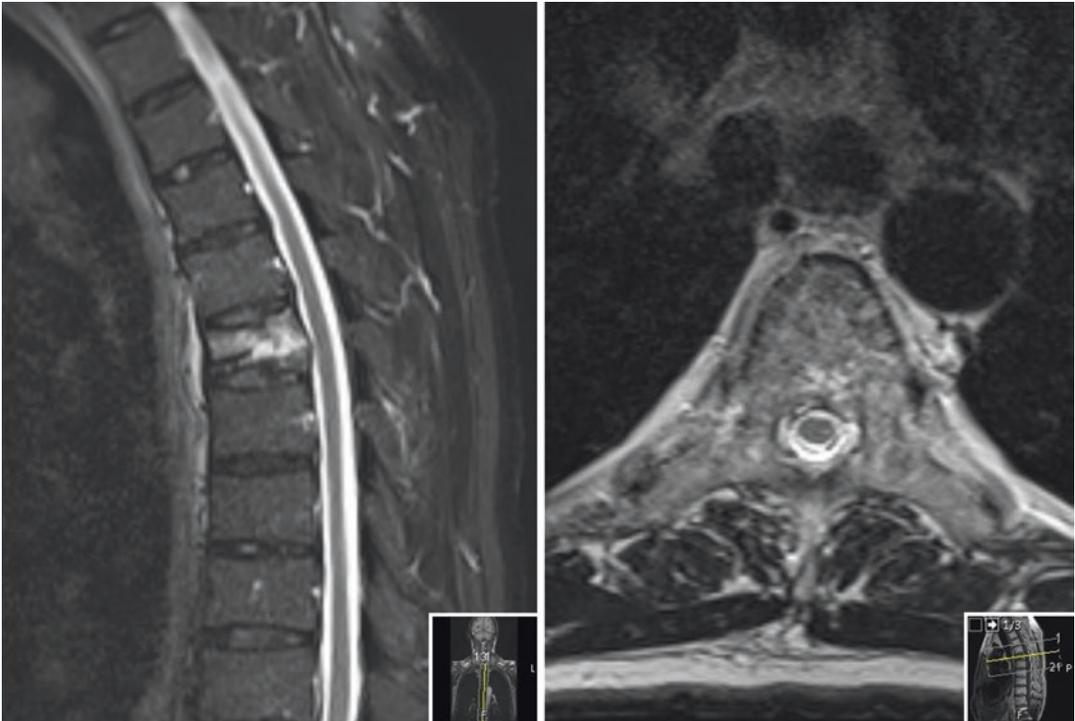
MRI Sagittal (left) and axial (right) MRI slices. A STIR (Short Tau Inversion Recovery) sequence was acquired, providing sensitivity to bone marrow edema.
